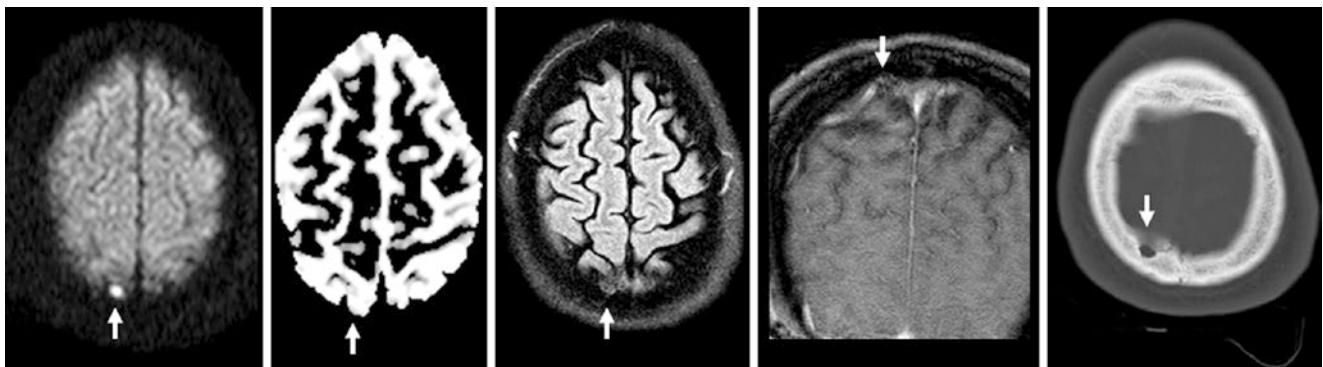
A 54 year old: on MRI, a tiny infarct (arrows) was questioned on DWI (left), but it had a bright signal on ADC map (T2 shine-through, left middle), intermediate FLAIR signal (middle), and no enhancement on T1WI (right middle). NECT confirmed a small arachnoid granulation
